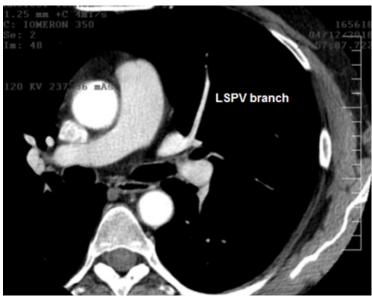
Computed tomography of the heart. A long branch of the LSPV heading to the left pleura can be visualized.
